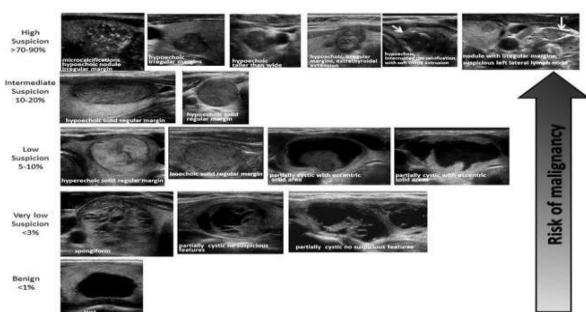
ATA nodule sonographic patterns and risk of malignancy.⁵
